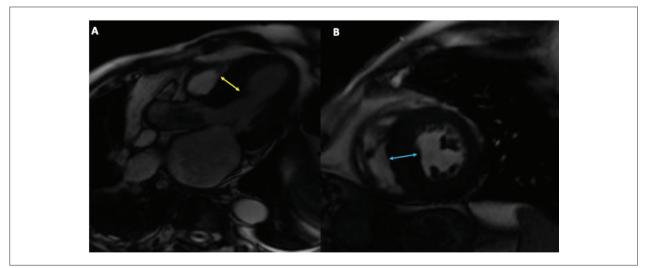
Cardiac Magnetic Resonance Imaging (CMR). Cine sequence show enlarged mass. The yellow marker shows the largest width of the LV septal hypertrophy in five chambers (A). The blue marker shows the largest width of LV in the short axis (B). LV: left ventricle.
